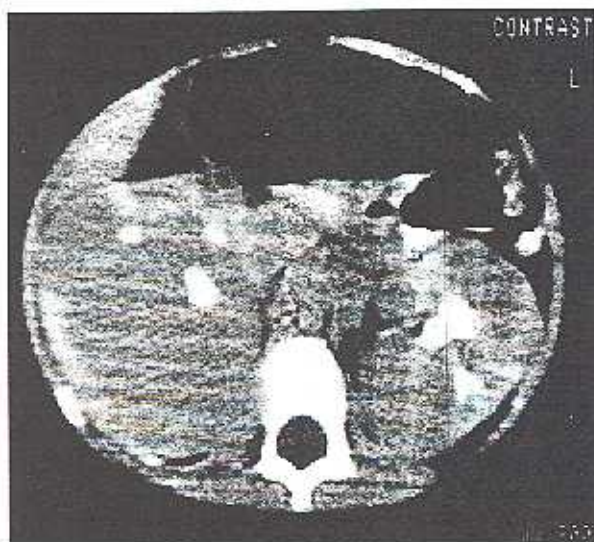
CT-scan with markedly enlarged kidneys; right more than the left. Prior to chemotherapy.
